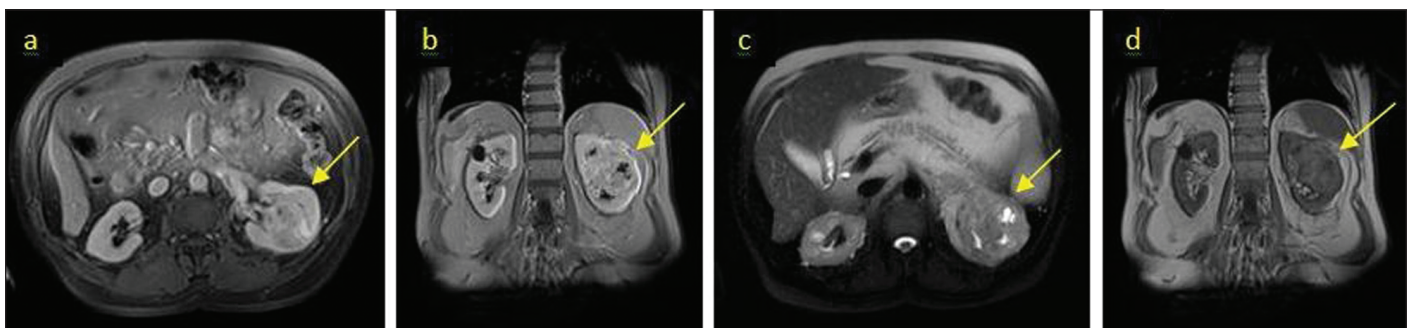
A: Magnetic resonance imaging (MRI) T2, mass in the central part of the left kidney with necrosis (yellow arrow); B: MRI T2, mass in the central part of the left kidney with necrosis and calcification (yellow arrow); C: MRI T1 shows a mass in the central part of the left kidney with necrosis and calcification (yellow arrow); D: MRI T1 showing a mass in the central part of the left kidney with necrosis (yellow arrow).
